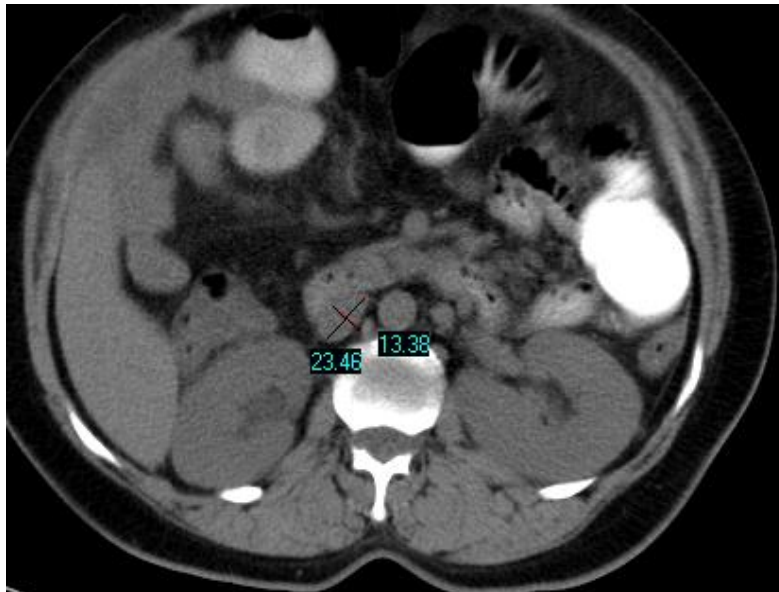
Axial CT Scan image showing inferior vena cava diameters measurements of 25 years old male at T12 level
